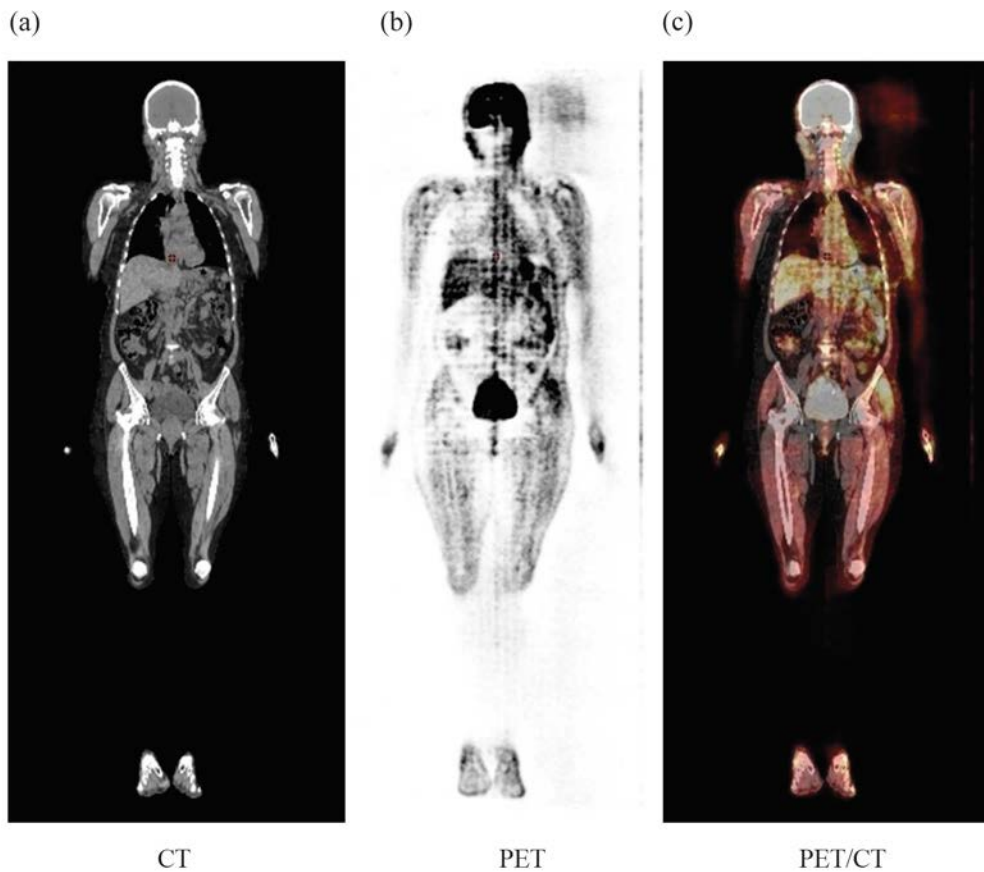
Coronal CT (a), PET (b) and fused images (c) of a whole body PET/CT patient study with timing calibration errors shown as a geometric pattern throughout the PET image.
